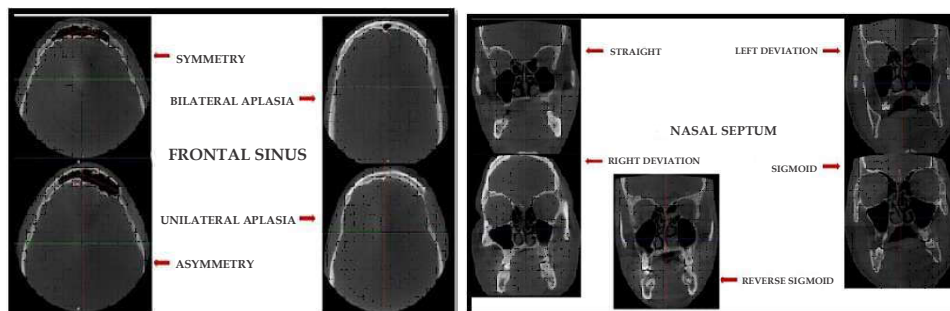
Planmeca 3 D CBCT images of Frontal Sinus and Nasal Septum Patterns [27].
